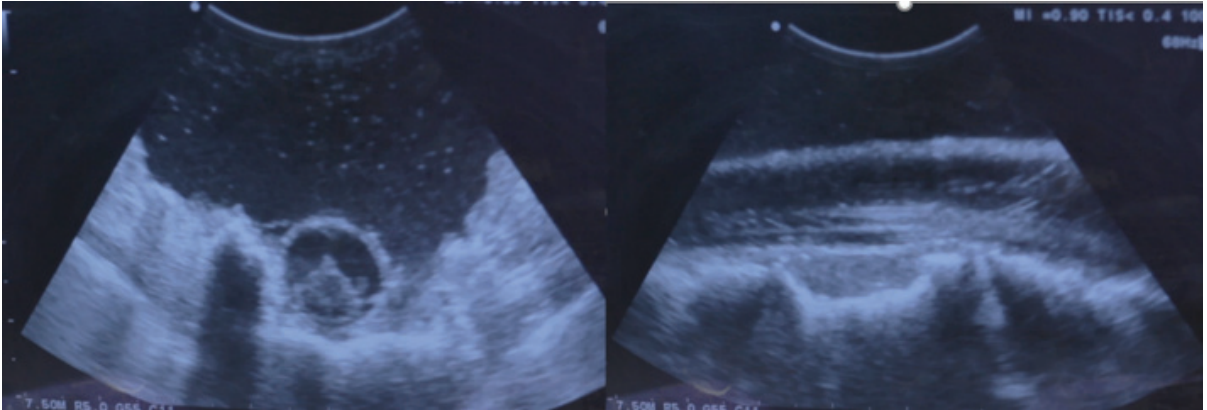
Patient 3: Intraoperative ultrasound – Representative ultrasound images acquired using conventional ultrasound.
